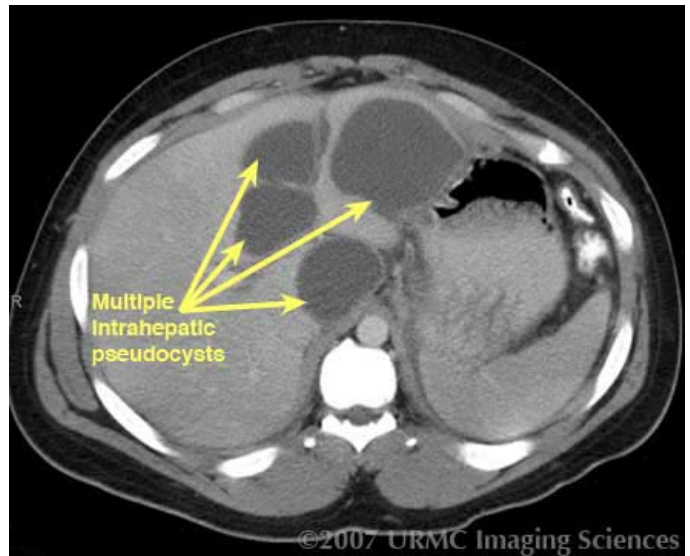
Axial CT image demonstrates intrahepatic pseudocysts.
